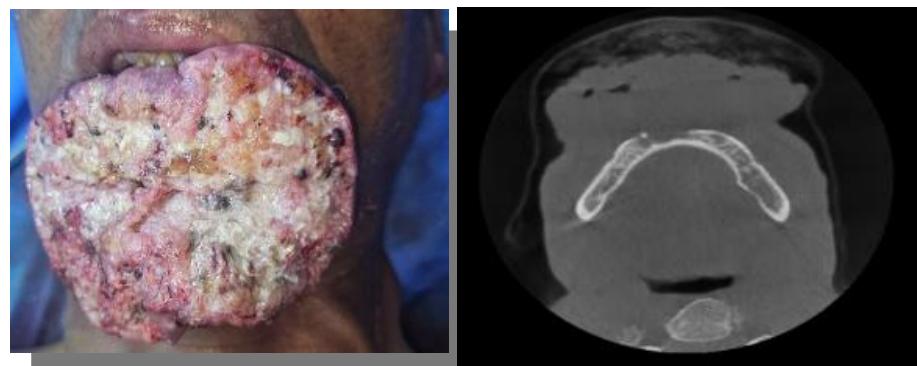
52 years old patient with squamous cell carcinoma (left: patient image, right: CBCT).
